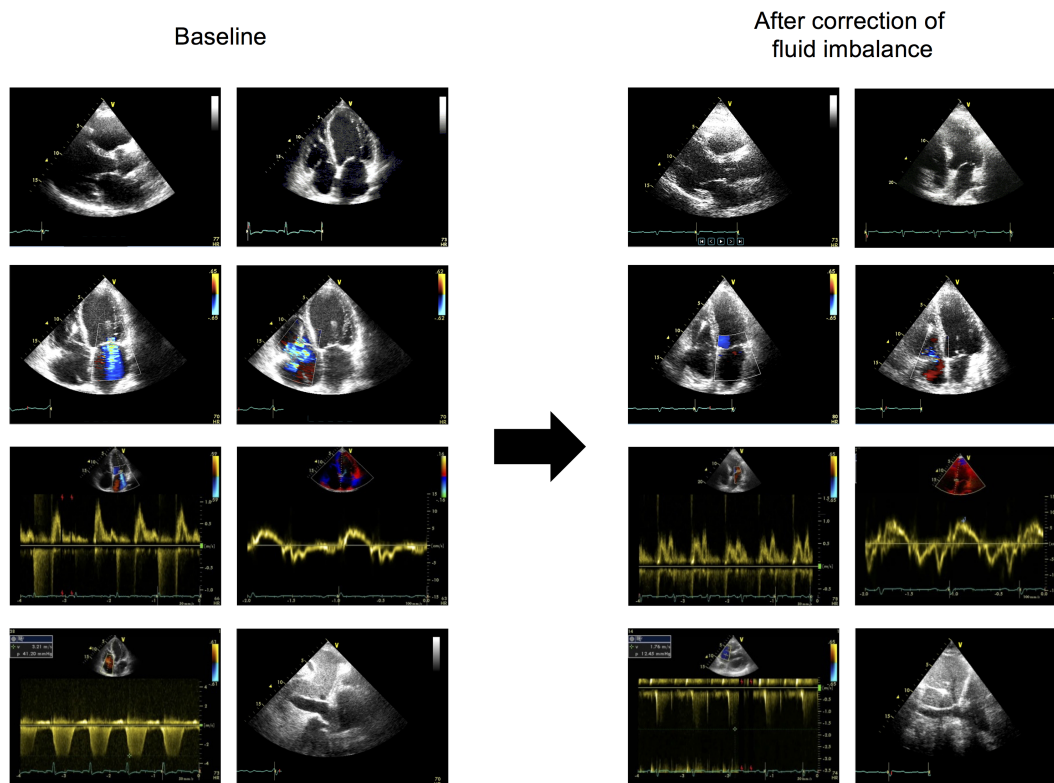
Echocardiographic examination of patient 1 before (left) and 12 months after (right) the correction of fluid imbalance. From top to bottom: Four-chamber view, mitral and tricuspid regurgitation, pulsed Doppler and tissue Doppler images obtained at the level of the mitral valve, and systolic velocity peak of tricuspid regurgitation and the inferior vena cava [Color figure can be viewed at wileyonlinelibrary.com]
